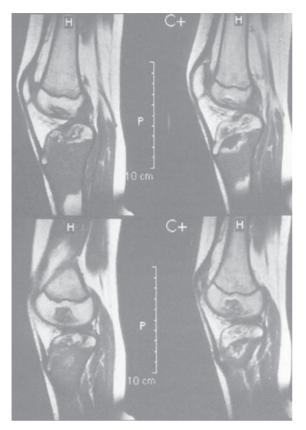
MRI shows bone infarcts in the proximal epiphysis of both tibias and an infiltrative lesion with hemorrhagic and cystic components in the proximal metadiaphysis of the right tibia.
